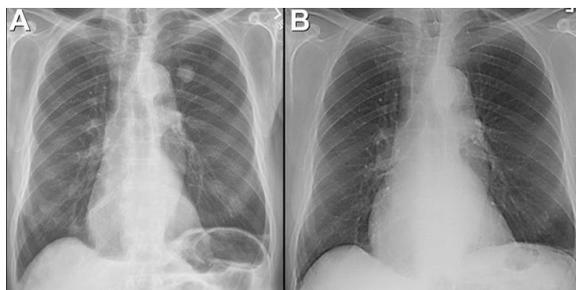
A: Frontal chest radiography. B: Frontal chest radiography performed just over 1 year prior to A shows no specific abnormalities.
